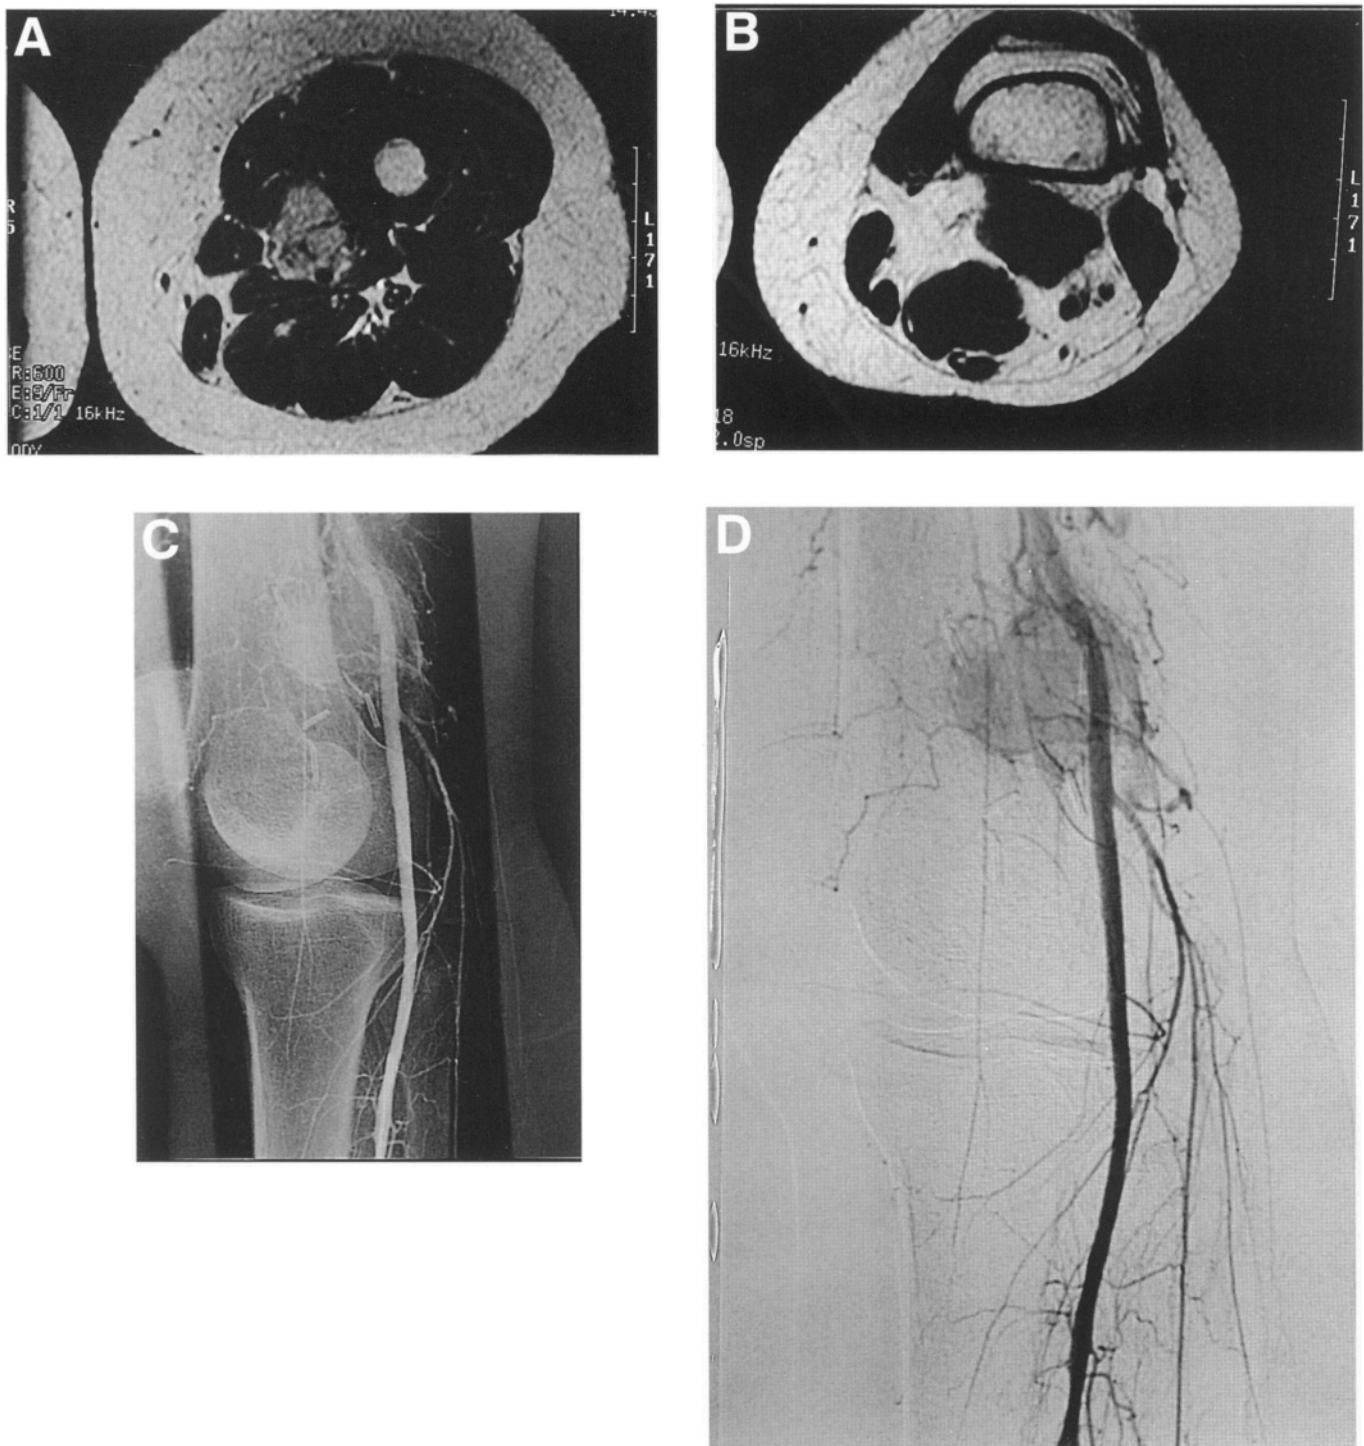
Leiomyosarcoma involvement of the sartorial canal and extension distally into the popliteal space. Evaluation of tumors of the thigh must include careful inspection of the sartorial canal and the superficial femoral artery and vein. Tumors arising within the sartorial canal are rare, but often travel superiorly along the anterior thigh below the sartorius muscle and distally into the popliteal space (as shown). (A) Tumor within the sartorial canal. The sartorius helps to orient the location of the lesion. (B) T1 weighted MRI scan through the popliteal space shows tumor extension into the popliteal space. The tumor tracks down the length of the superficial femoral artery and may be located extremely proximally or distally to the original tumor mass. (C) Lateral angiogram of the same tumor showing a tumor blush circumferentially located around the superficial femoral artery. (D) Subtraction angiogram showing tumor blush at the level of the popliteal space and the sartorial canal. This patient was treated by wide excision of the vastus medialis and the sartorial canal along with the superficial femoral artery and vein, and was reconstructed with a long Gore-Tex[®] graft. The tumor arose from the popliteal vein.
